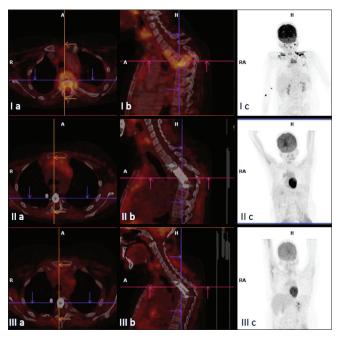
Positron emission tomography-computed tomography ([a-c; axial, sagittal, maximal intensity projection], [I-baseline, II-3rd month, III-18th month]) - fluorodeoxyglucose avidity (Standardized uptake value max-18.4) with Anterior wedging of T3/T4 vertebral bodies associated with posterior cortical bulging (gibbus), kyphotic deformity and extensive cervical (Standardized uptake value max-12.7)/mediastinal lymphadenopathy (Standardized uptake value max-13.7). Underwent Lateral Internal fixation with metallic cage. No fluorodeoxyglucose avid focus at 3rd month and 18th month scan
